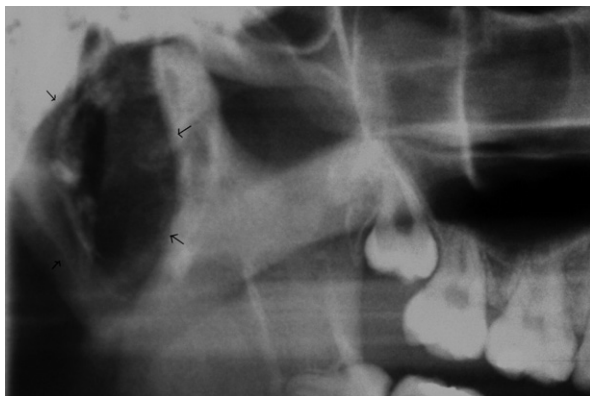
Panoramic radiograph reveals a well-circumscribed, mixed radiolucent-radiopaque mass on the posterior border of the mandible, measuring about 3 × 4 cm (arrows).
